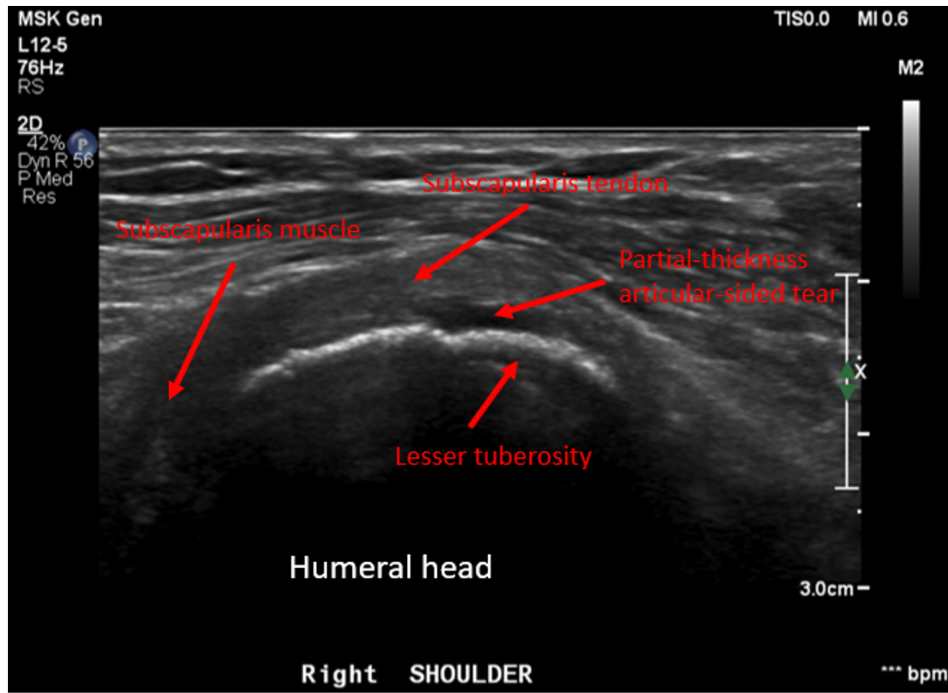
Patient #4 representative 6-month post-operative ultrasound showing a mostly (> 75%) intact subscapularis tendon with normal fibrillar echogenic tendon architecture and thickness, with a low-grade partial-thickness tear (< 25%)
